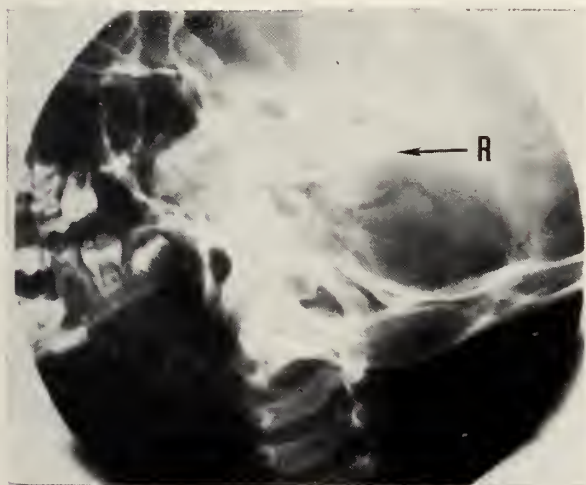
Diagnosis of acute mastoiditis is made by radiographic evidence of clouding and loss of separation of mastoid air cells giving the mastoid a "ground glass" appearance.
